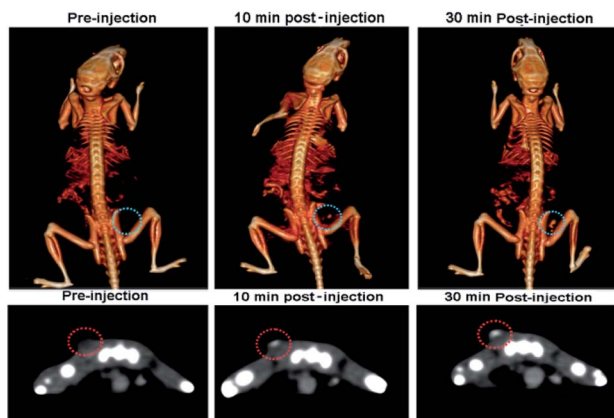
Time-dependent CT images of the tumour after intratumoral injection of PEG-coated  $\text{Bi}_2\text{S}_3$  nanodots.
